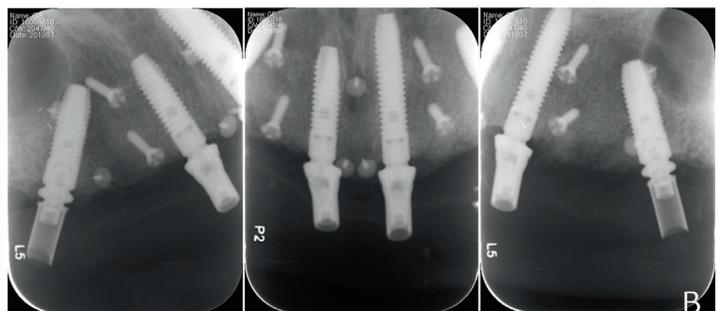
Interim restoration in place. A, Intraoral view. B, Periapical radiographs.
